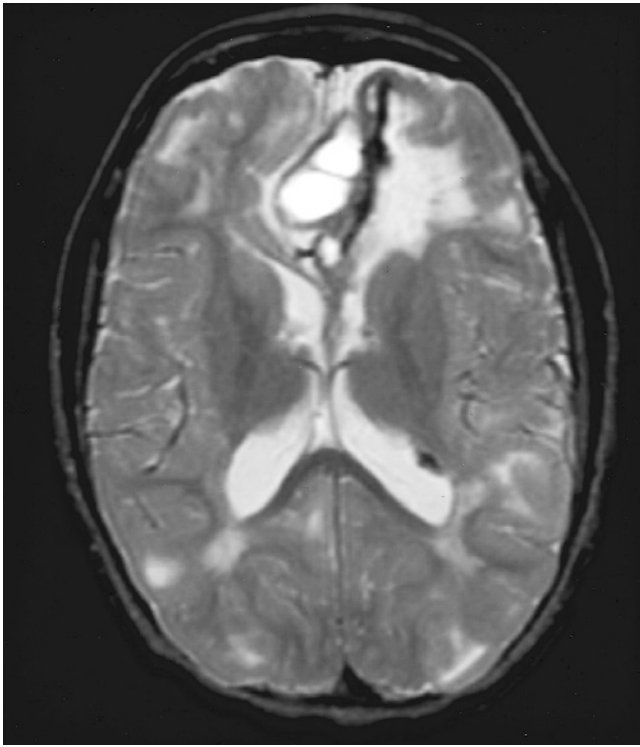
Tuber with cystic degeneration on axial T_2 -weighted magnetic resonance image, seen as a high-intensity subcortical lesion. Courtesy of D. N. Franz, Cincinnati, OH.
